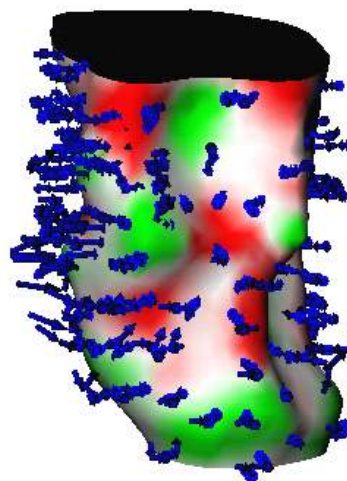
Shape-tracked dense endocardial displacement vector field of a MRI dataset from ED to ES, sub-sampled for visualization purposes. The trajectories are shown against the rendered endocardial Gaussian curvature map at ES.
